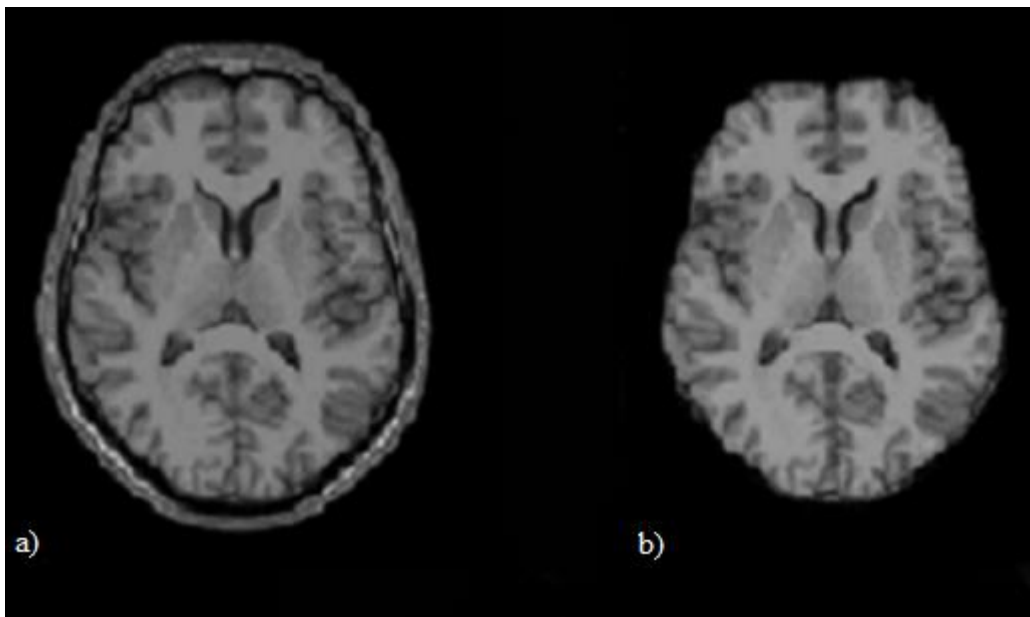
a) Axial view of a T1-weighted input image and b) the same slice after skull stripping. These images are taken from a representative subject of the present study.
